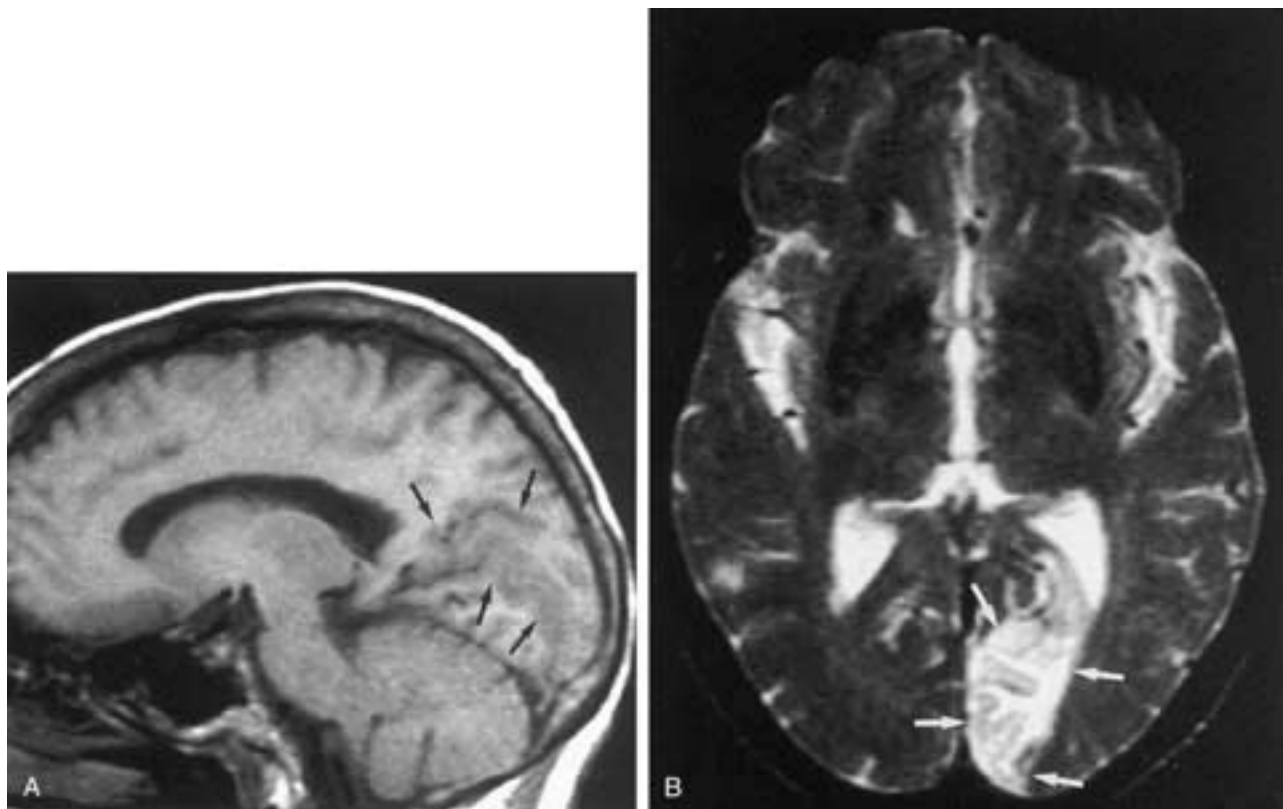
Left occipital infarct in a 50-year-old male with abrupt onset of right homonymous hemianopsia. A, Sagittal T1-weighted MR image without contrast injection shows decreased signal intensity involving the cortex (*arrows*) above and below the calcarine fissure. B, Axial T2-weighted MR image shows high signal intensity involving the cortex and subjacent white matter (*arrows*) in the left temporooccipital region including the calcarine cortex.
